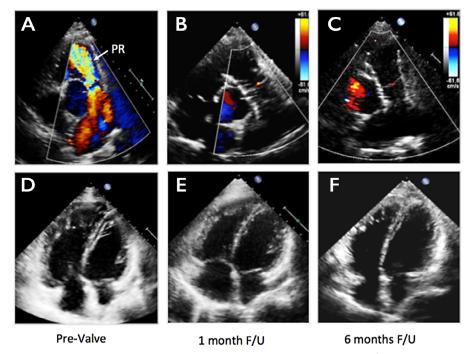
Series of color (*Panels A, B, C*) and two-dimensional transthoracic echocardiography four-chamber view images performed at baseline (*Panels A, D*), 1-month follow-up (*Panels B, E*), and 6-month follow-up (*Panels C, F*) in a 20-year-old female patient after surgical closure of ventricular septal defect and right ventricle outflow obstruction using a patch. She had severe pulmonary regurgitation. These images demonstrate sustained resolution of free pulmonary regurgitation and significant remodeling of the right ventricle. The white arrow in the *Panel A* image indicates severe pulmonary regurgitation, and the images in *Panels B and C* demonstrate a competent Venus P-valve (26 mm) with trivial if any regurgitation. The *Panel D* image shows a large right ventricle, and the images in *Panels E and F* show significant remodeling of the right ventricle at 1- and 6-month follow-up, respectively.
